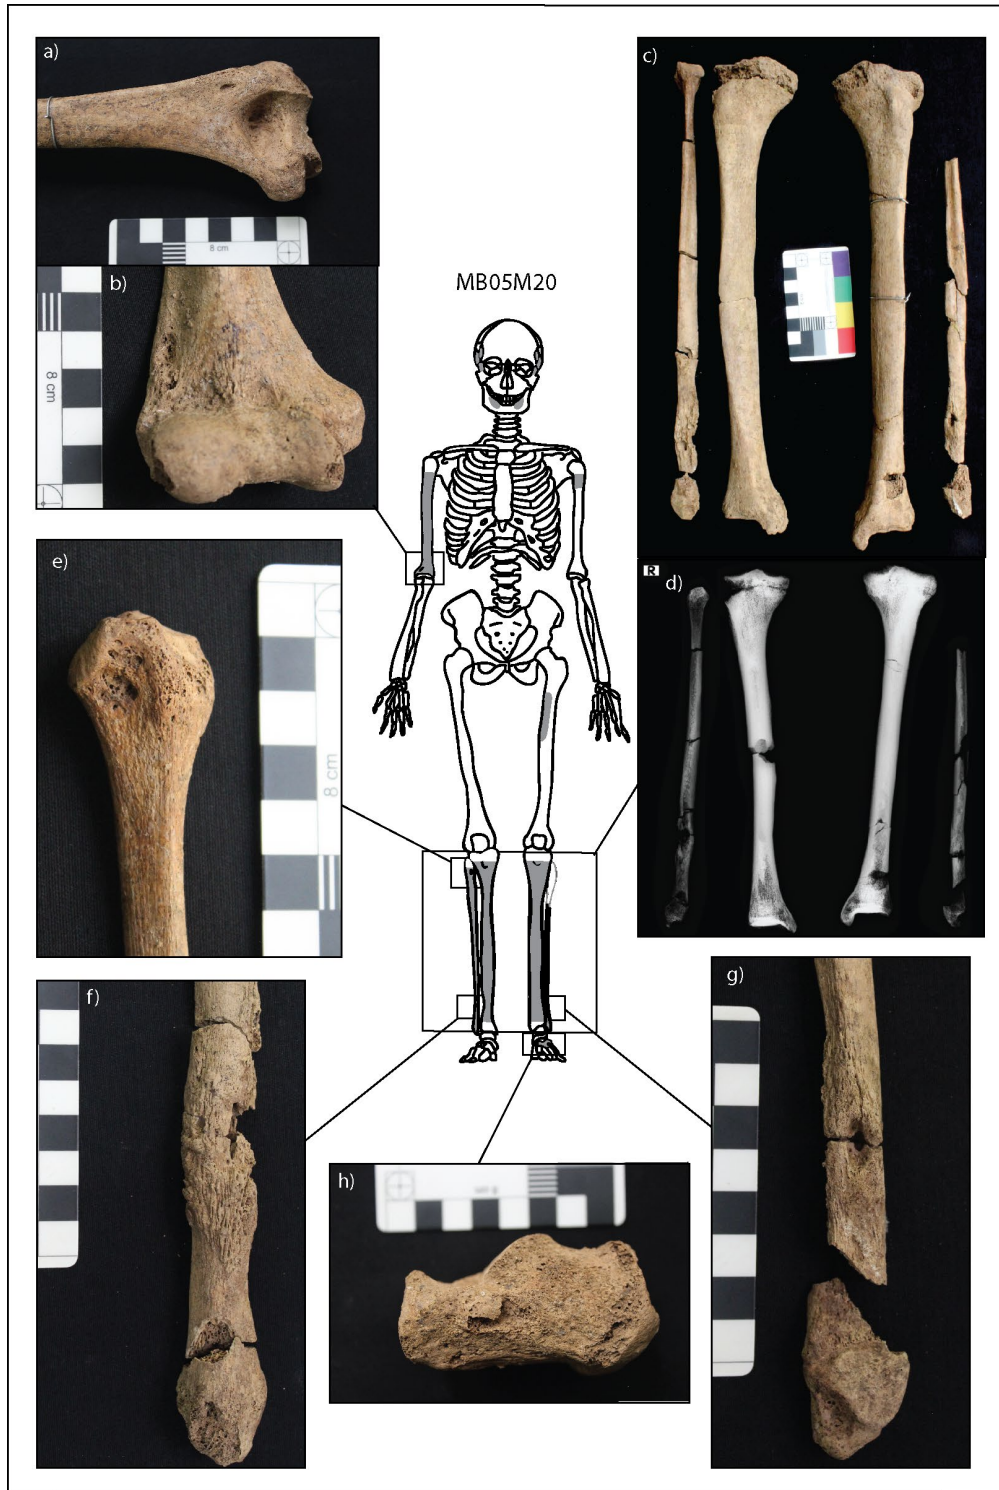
Expression of lesions related to infectious disease in MB05M20. Preserved bones are outlined in black, with absent bones outlined in light grey. The skeletal extent of osteoblastic lesions is indicated by dark grey fill. a) and b) Superficial focal cavitations with smooth sclerotic margins not within distinct nodes of SPNB on the anterior and posterior lateral epicondyle of the right humerus. c) Cortical enlargements throughout the shafts of the tibiae with striated nodes of SPNB on the distal fibulae. d) Radiographs of the tibiae and fibulae: a distinct node of new bone with medullary intrusion is present on the medial middle shaft of the right tibia. e) Superficial focal cavitation not within a distinct node of SPNB on the proximal right fibula. f) Two focal superficial cavitations on the lateral aspect of the right distal fibula within a distinct node of striated new bone. g) Focal superficial cavitation on the medial aspect of the right distal fibula within a distinct node of striated SPNB. h) Focal superficial cavitation on the medial left calcaneal body, not within a distinct node of SPNB. Image: author's own from Vlok et al. (2020).
